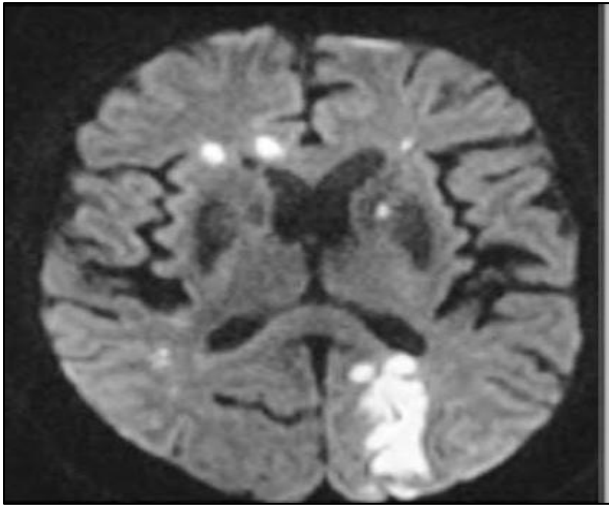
MRI brain DWI embolic infarcts.
